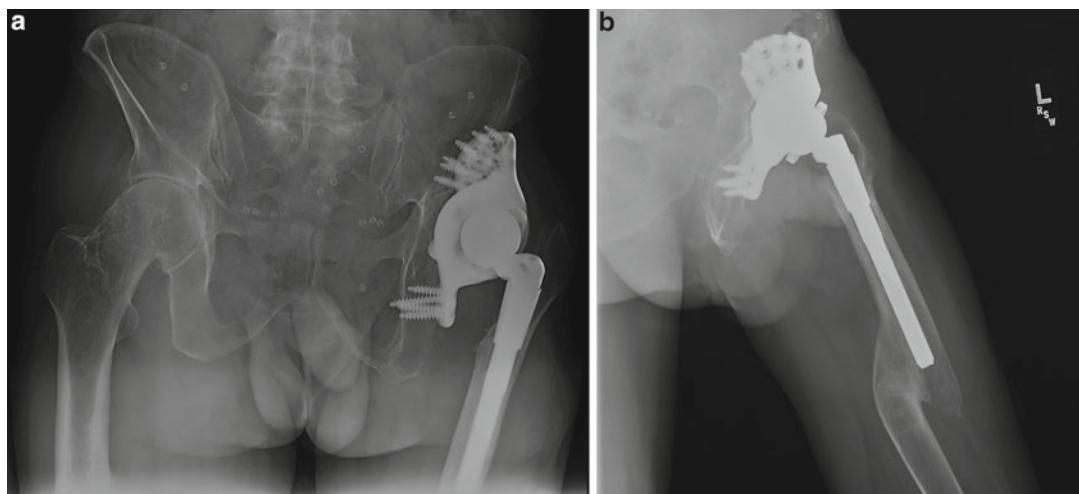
(a, b) AP pelvis and lateral hip radiographs after conversion to total hip arthroplasty. Preoperative serum sedimentation rate and C-reactive protein value were normal. Attempts at aspiration of the hip were unsuccessful. Given the global, segmental acetabular bone deficiencies, a custom, porous-coated acetabular
